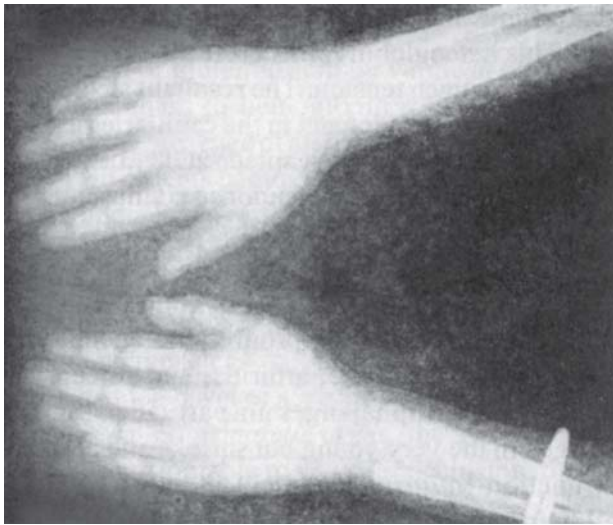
X-ray hand and forearm showing thinning of the cortex and coarsening of trabeculae in thalassemia major
